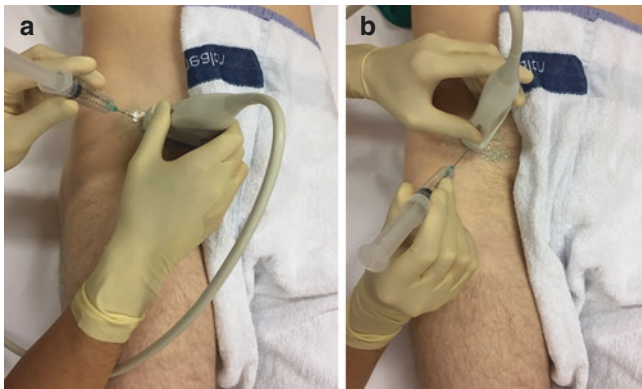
Patient positioning. Lateral to medial approach. (a) The needle is advanced under ultrasound guidance, using a lateral to medial approach up to the deep lateral portion of the iliopsoas tendon, following the plane of the transducer. Sagittal approach. (b) The transducer is orientated following the axis of the femoral head and neck, and the iliopsoas tendon is identified lateral to the neurovascular bundle
